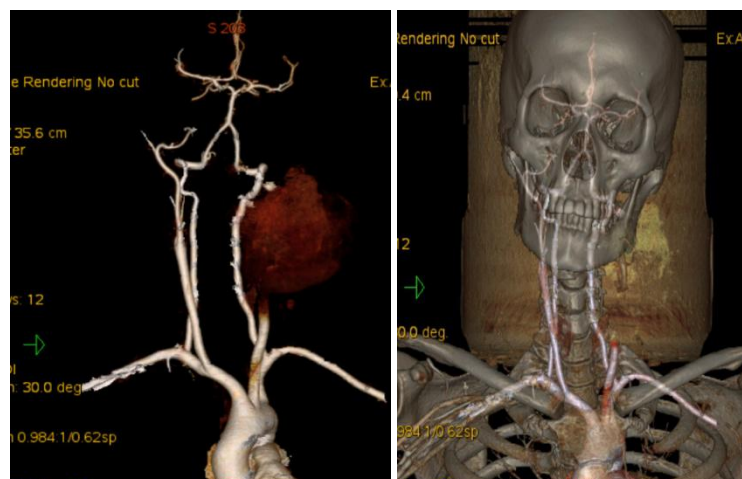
Contrast-enhanced CT Scan of The Head and Neck with Three-Dimensional Vascular Reconstruction Showing Blood Flow Filling The Left Cervical Cavity
